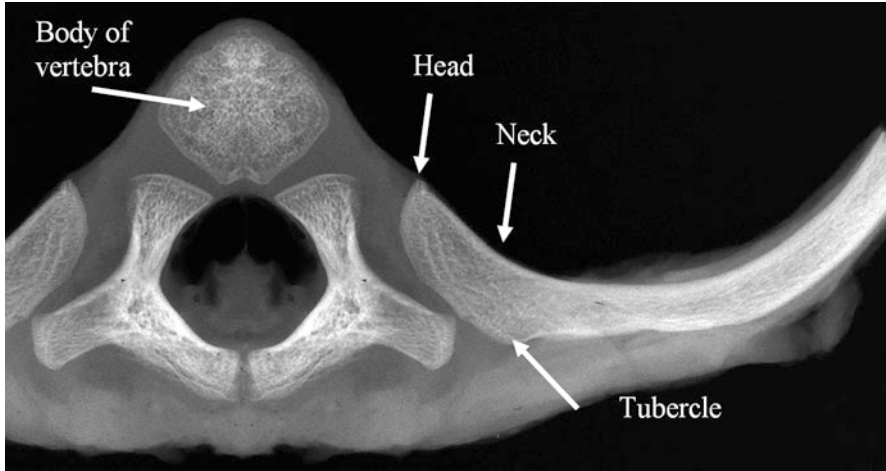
Radiograph of a resected vertebral body with the posterior arcs of the ribs (normal infant)
